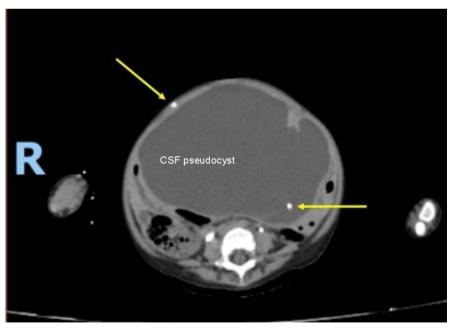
CT image showing the giant abdominal CSF pseudocyst. Arrows show the catheter on the left, still in the intramural pathway of the abdominal wall; and on the right, inside the large cyst.
